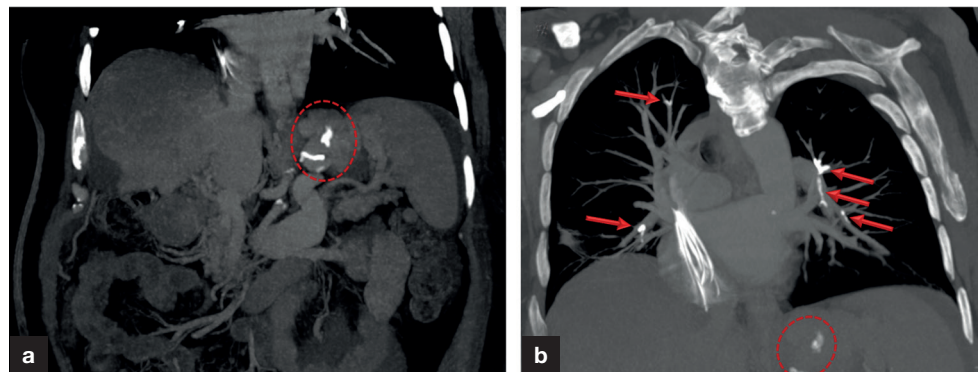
a. Coronal abdominal computed tomography shows hyperdense curvilinear materials (circles) at the gastric fundus extending into the lumen of the perigastric varices. b. Coronal maximum intensity projection computed tomography scan reveals multiple opacities cause to the filling defects of bilateral pulmonary artery branches (arrows).
